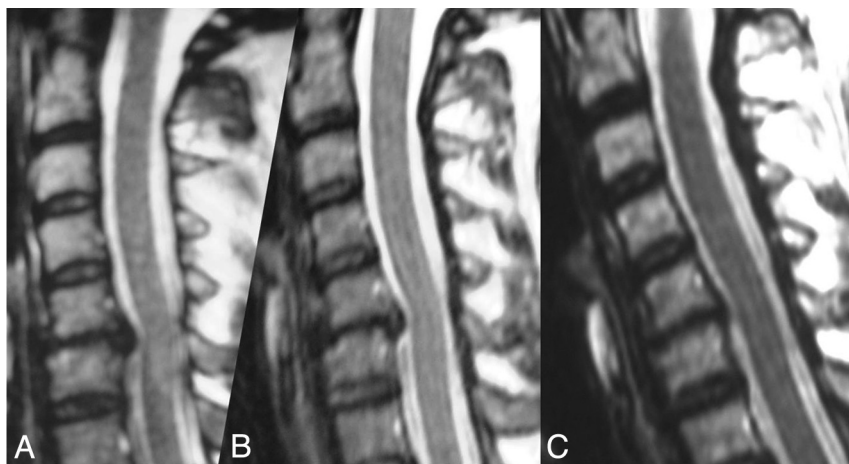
A*, MR image before treatment in a patient with cervical and radicular pain and a C5-C6 disk hernia. *B*, MR image 6 weeks after treatment with minimal change in the morphology of the hernia, but the patient is clinically asymptomatic. *C*, MR image 4 years after treatment shows complete disappearance of the disk hernia. The patient remains asymptomatic.
